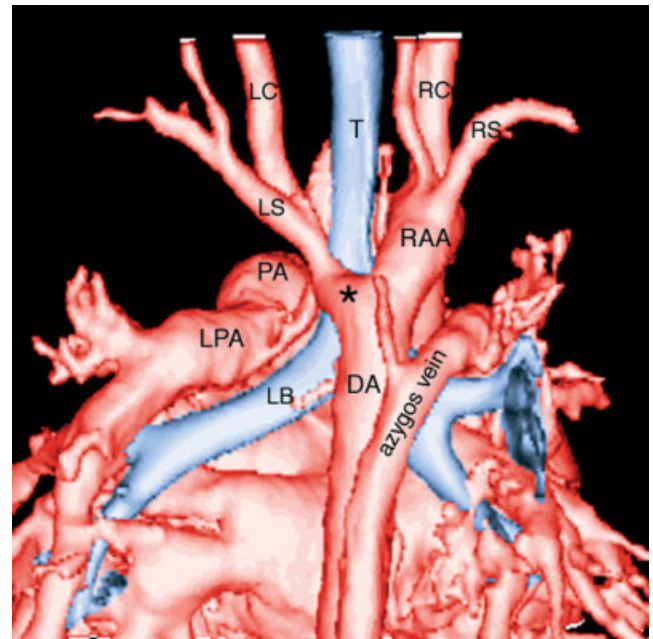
Right aortic arch with aberrant left subclavian artery in a 9-month-old child. Contrast-enhanced three-dimensional computed tomography image seen from behind shows the right aortic arch (RAA) and the aberrant left subclavian artery (LS) arising from the diverticulum of Kommerell (asterisk) of the descending aorta (DA). The presence of diverticulum suggests that a left ligamentum ductus connects the apex of the diverticulum and the proximal left pulmonary artery (LPA), completing a vascular ring. As an incidental finding, the right vertebral artery has a separate origin from the right aortic arch between the right common carotid (RC) and right subclavian (RS) arteries. LC, left common carotid artery; LB, left main bronchus; PA, pulmonary artery; RS, right subclavian artery; T, trachea.
